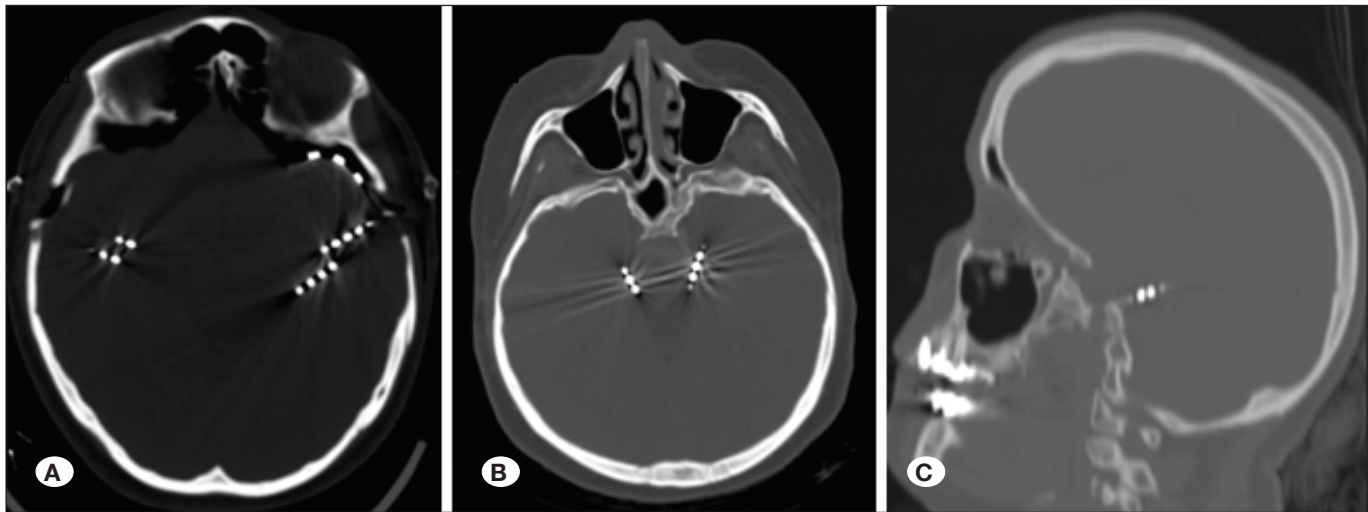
Neuroradiological images of patients who underwent invasive monitoring. A) CT image showing a strip and grid electrodes bilaterally on the axial section. Depth electrodes implanted bilaterally via the foramen ovale can be observed on the axial (B) and sagittal (C) sections.
